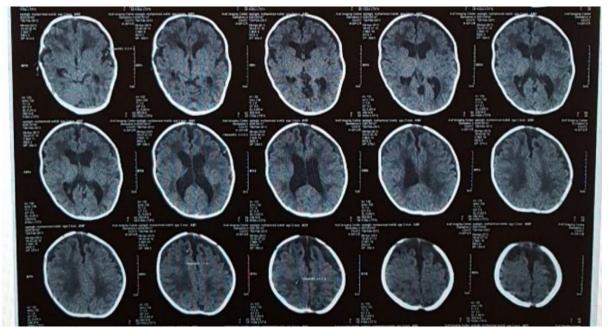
Non-contrasted spiral computed tomography scan; dilatation in ventricles, frontotemporal atrophy, and periventricular hypodensity
